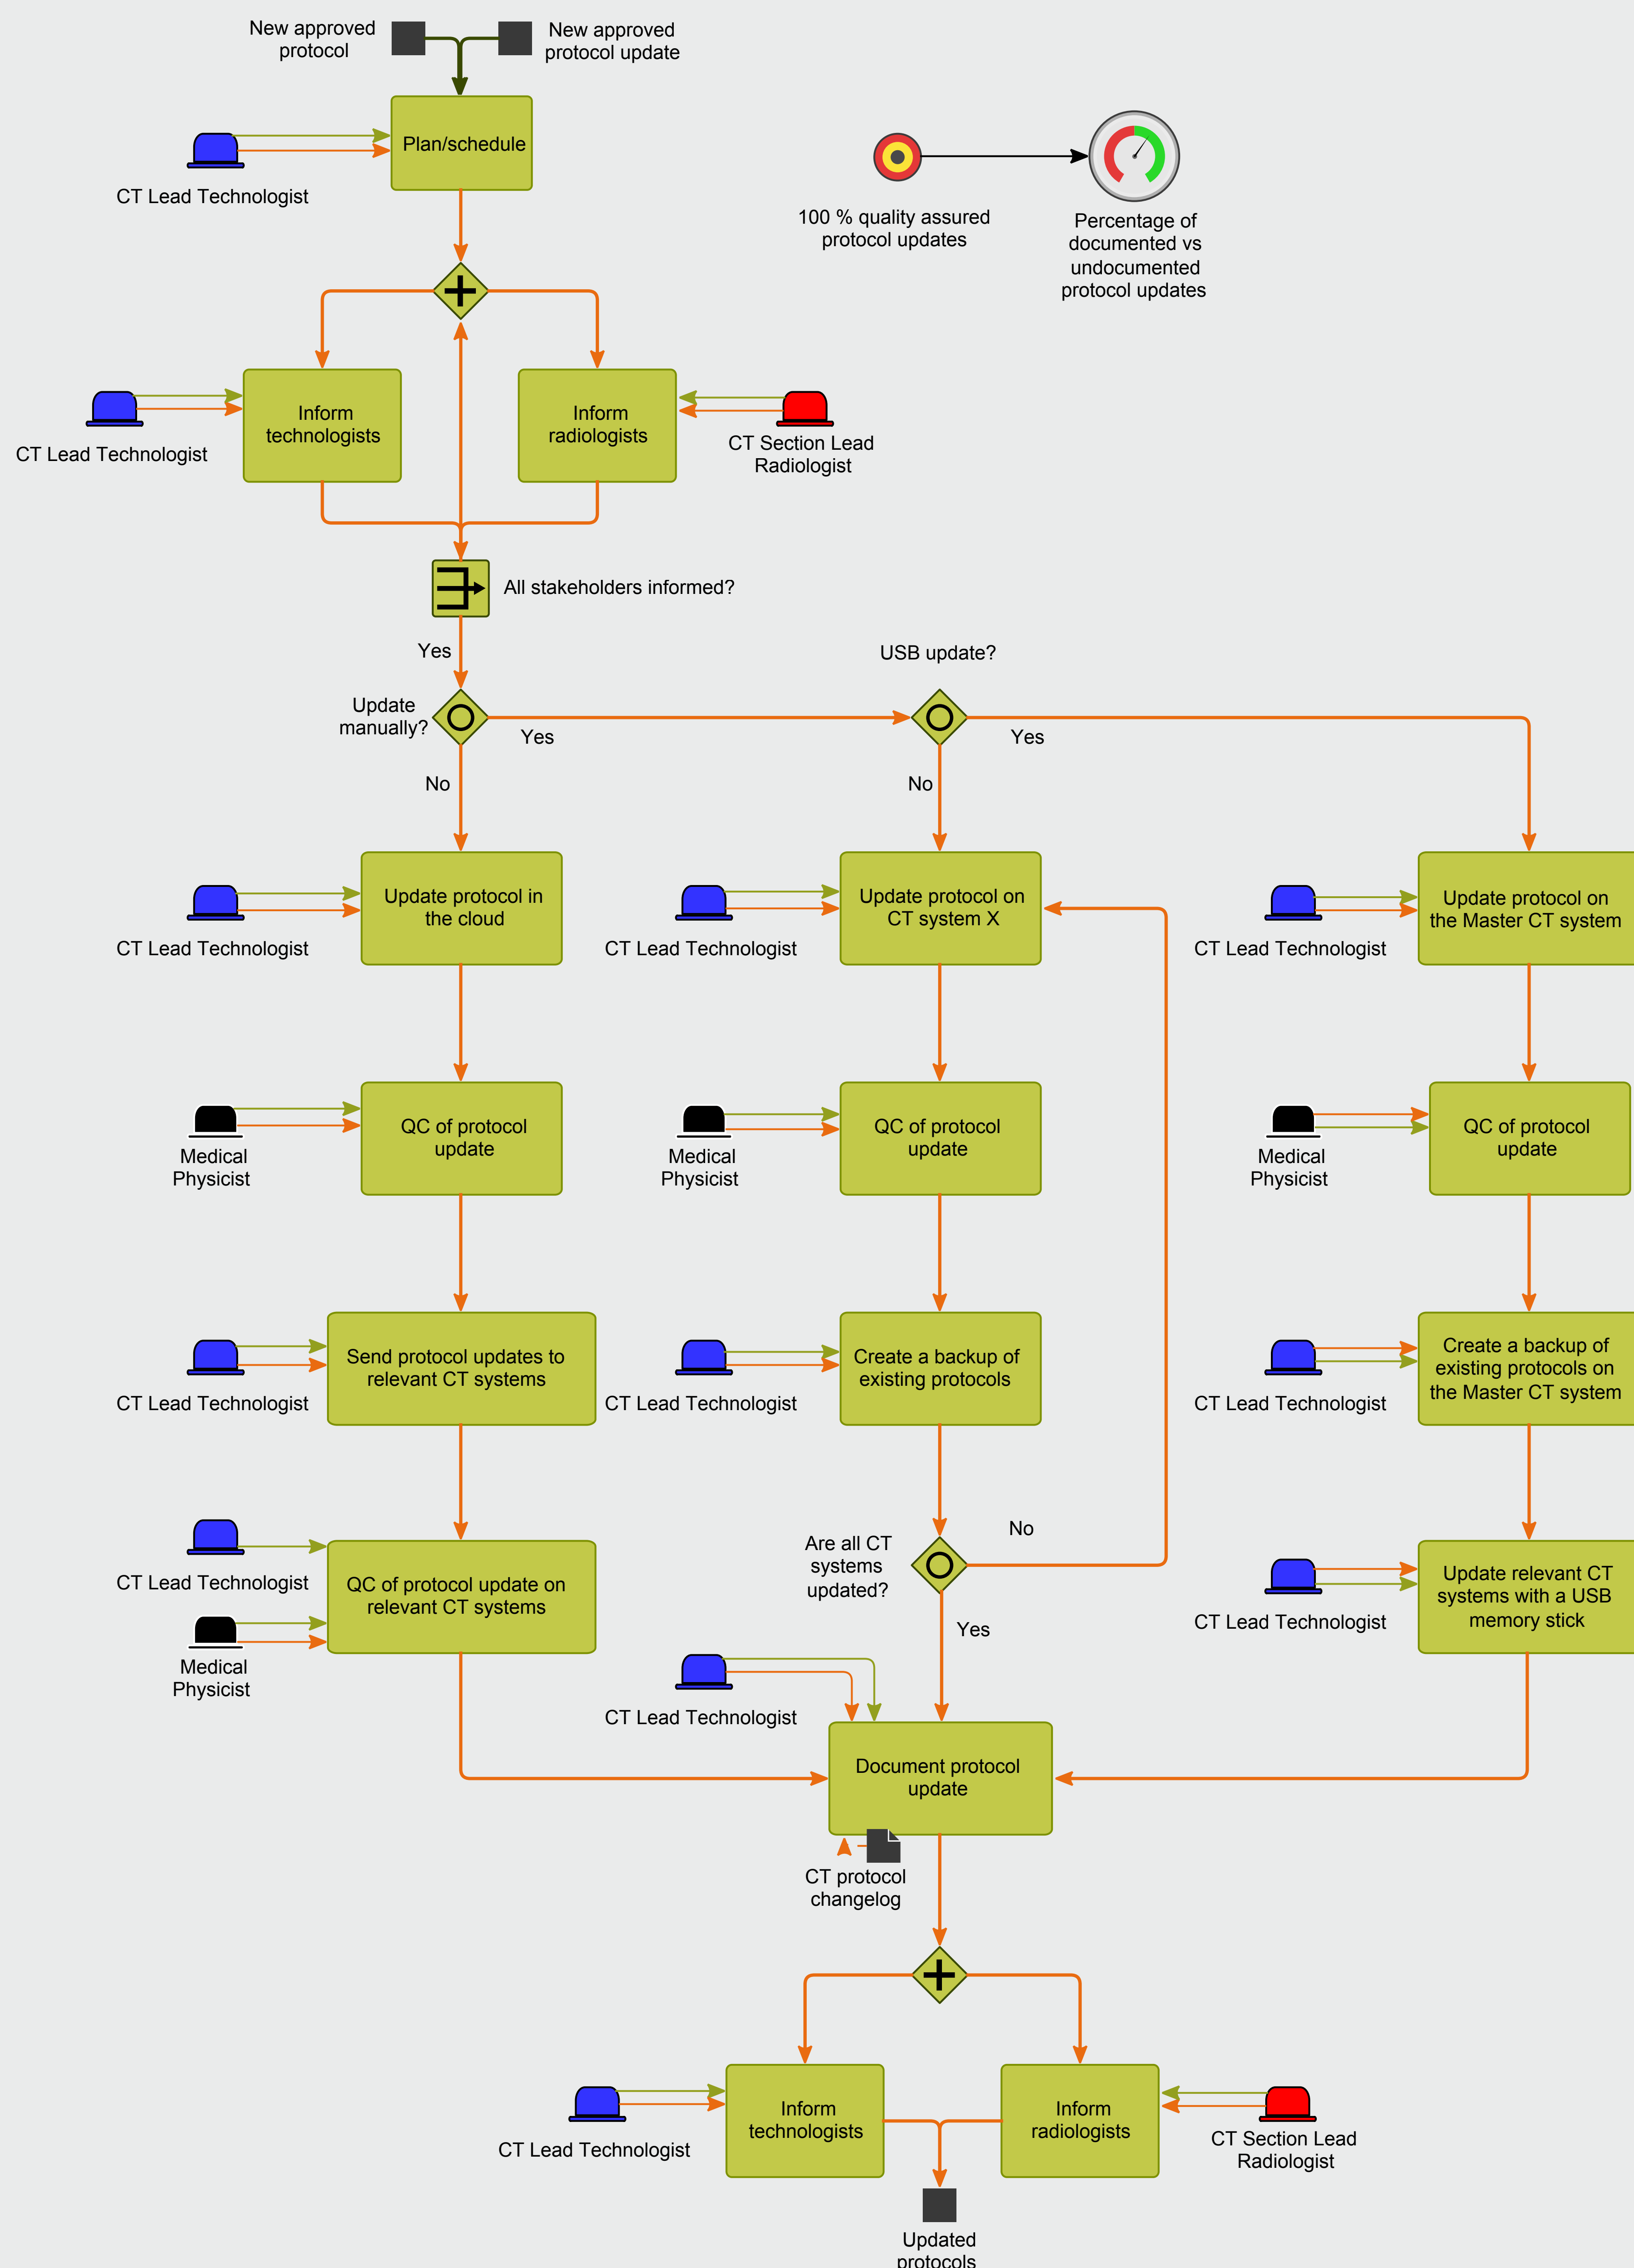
An example of a completed component which describes the process for implementing new or updated protocols on CT scanners. Several incidents at our facility can be attributed to the lack of such a well defined process for updated protocols on CT scanners.
